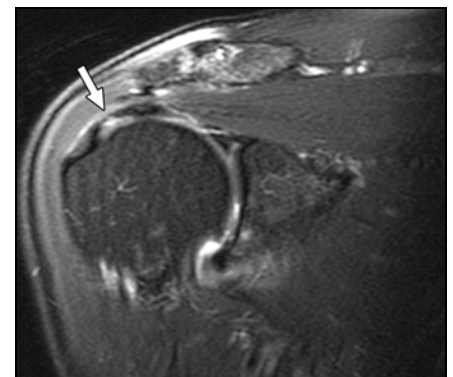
58-year-old woman with critical zone partial-thickness tear. Coronal oblique fat-suppressed fast spin-echo T2-weighted (TR/TE, 4,000/67) MR image shows partial-thickness, articular-sided tear of supraspinatus tendon 1–2 cm proximal to its insertion, in so-called critical zone (arrow).
